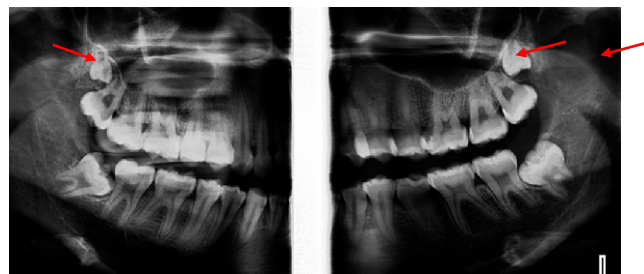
Panoramic radiograph (sectional panoramic radiograph) of 18-year-old female patient with maxillary distomolars intricately related to the maxillary tuberosity and the floor of the maxillary sinus bilaterally.
